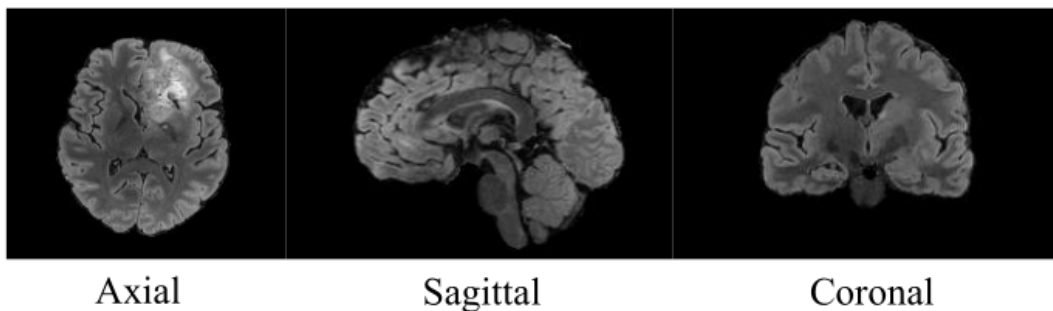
MRI in three diagnostic planar views: axial, sagittal, and coronal. The image is sourced from the BraTS dataset, acquired utilizing the ITK-SNAP software application [Yushkevich et al. (2006)].
